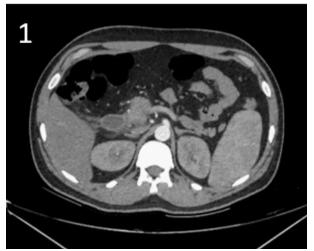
Fluid with fat stranding is seen around the second part of the duodenum on axial contrast enhanced CT image. Minimal fat stranding is seen extending to the subhepatic region.
